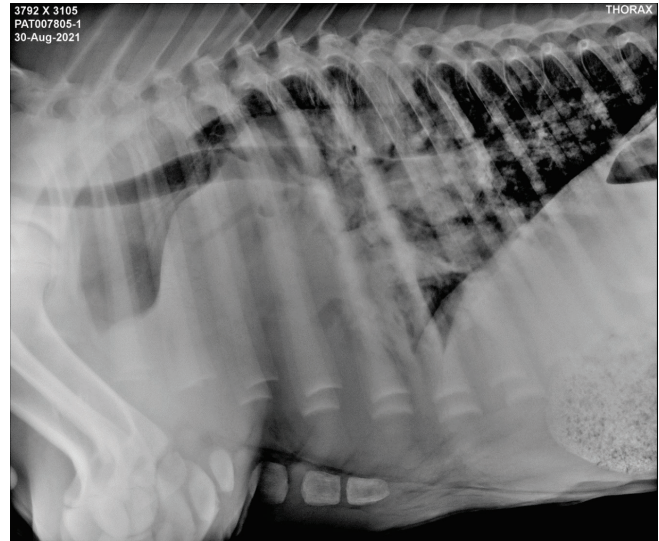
Radiograph of chest (lateral view) showing multiple soft tissue opacities in caudal lung lobe and alveolar pattern in the cranial and middle lung lobes
